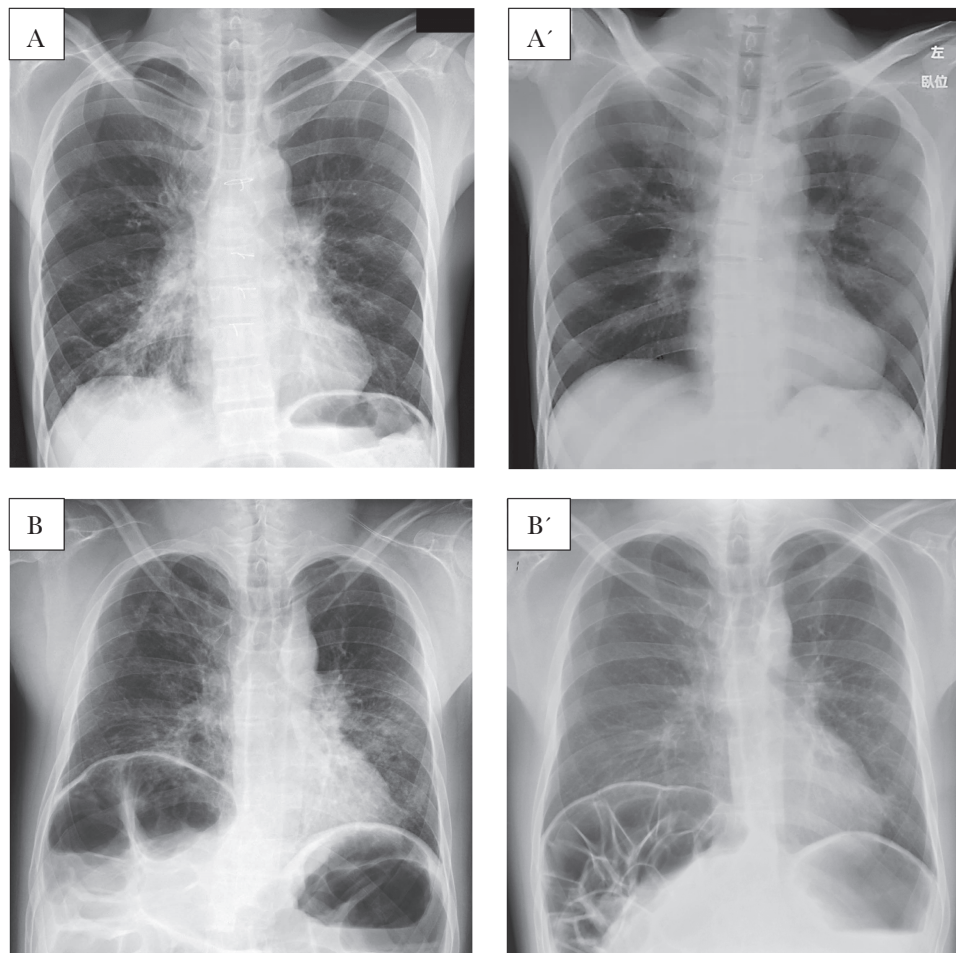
Representative chest x-ray images for human metapneumovirus pneumonia. Bronchial wall thickenings radiating outward from the hilum and patchy infiltrations were seen during the outbreaks (A and B). Postinfection images demonstrate abnormal shadows were diminished along with symptoms (A', B'). Chest x-rays obtained from a (A) 44-year-old male and (B) 36-year-old male are shown.
